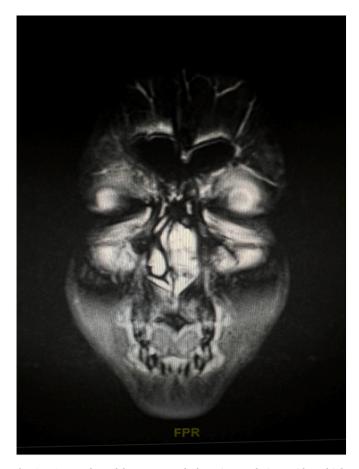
T2 MRI showed heterogeneously hyperintense lesions with multiple flow voids.
